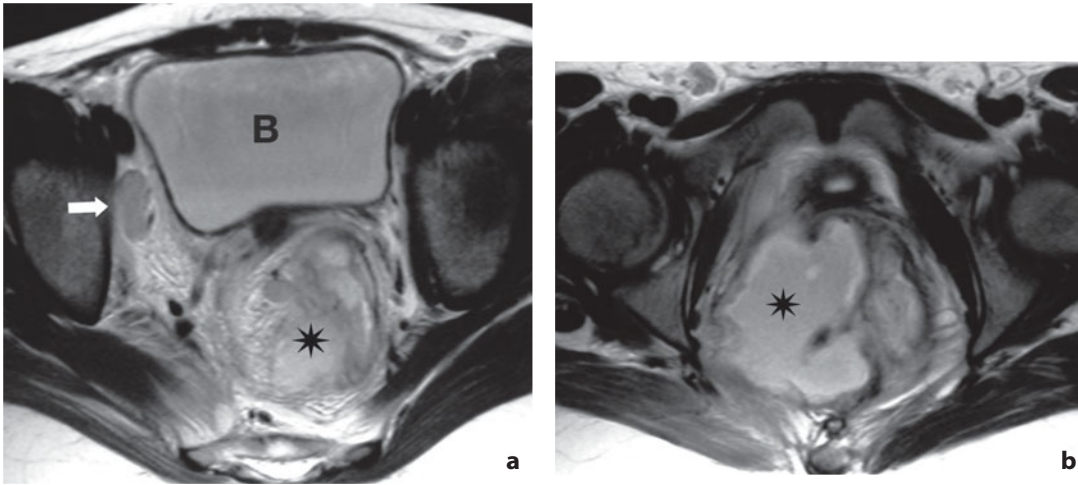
Magnetic resonance. Abscess of uterine tube. a Axial T2-weighted image shows a circumscribed heterogeneous collection (*asterisk*) located in the adnexae. The *arrow* indicates an enlarged right external inguinal lymph node due to inflammatory reaction. b More caudal plane shows saccular liquid collection also involving the right ischiorectal fossa. *B*, urinary bladder
